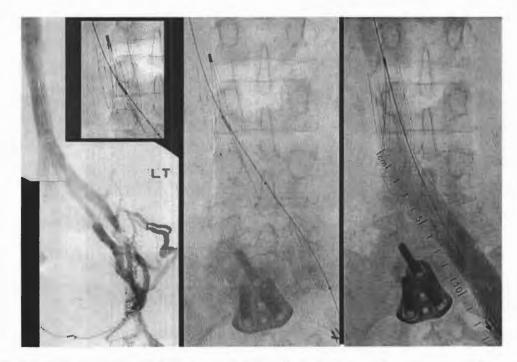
Left, Venogram showing left postthrombotic iliofemoral vein obstruction with previously placed inferior vena cava (IVC) filter (*inset*). Middle, The obstruction and filter are traversed by a guidewire and intravascular ultrasound (IVUS) has shown no stenosis or thrombus. Right, The caudad obstruction has been dilated and stented. The cephalad termination of the stent is below the untouched IVC filter.
